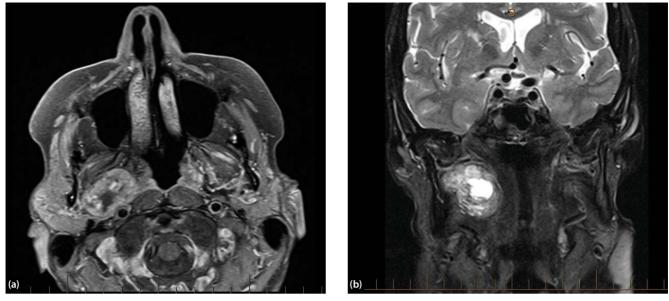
(a) MRI of right parapharyngeal space tumour. Lesion of the right parapharyngeal space with fat plane between tumour and deep lobe of parotid gland and rim of fat antero-medial to tumour. Lesion of the parapharyngeal space in the pre-styloid compartment displacing the carotid artery posteriorly. This variation is ideal for a TORS approach to resection. (b) Right parapharyngeal space tumour displacing carotid artery laterally. Favourable for TORS.
